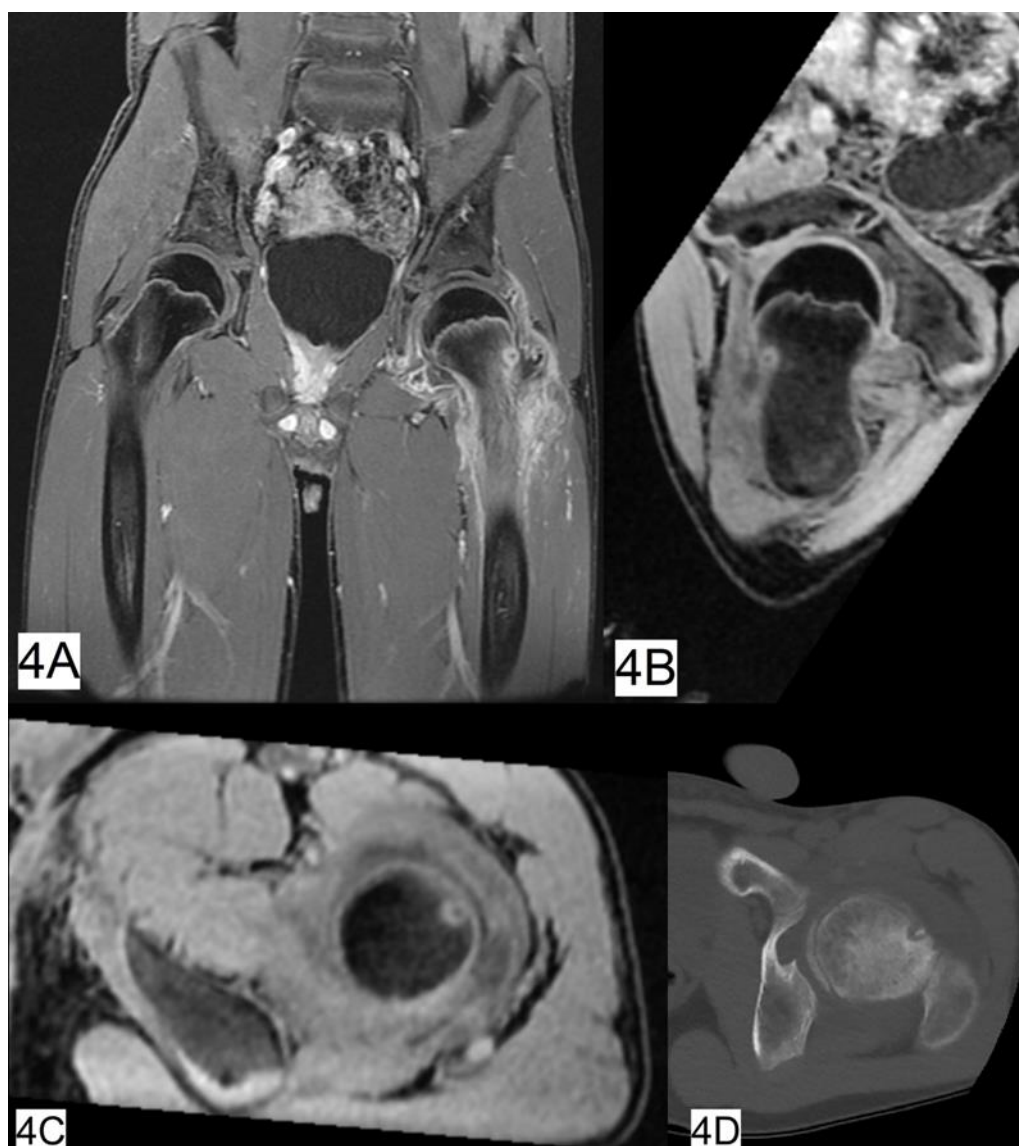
A- Case no. 13, MRI image showing infiltration of the soft tissues and proximal left femoral metaphysis with massive intraarticular effusion. B - Case no.13, MRI transversal section within femoral neck. C - Case no.13, MRI sagittal section within femoral neck. D - Case no.13, CT transversal section within femoral neck revealing the nidus in the anterior cortex of the left femoral neck.
